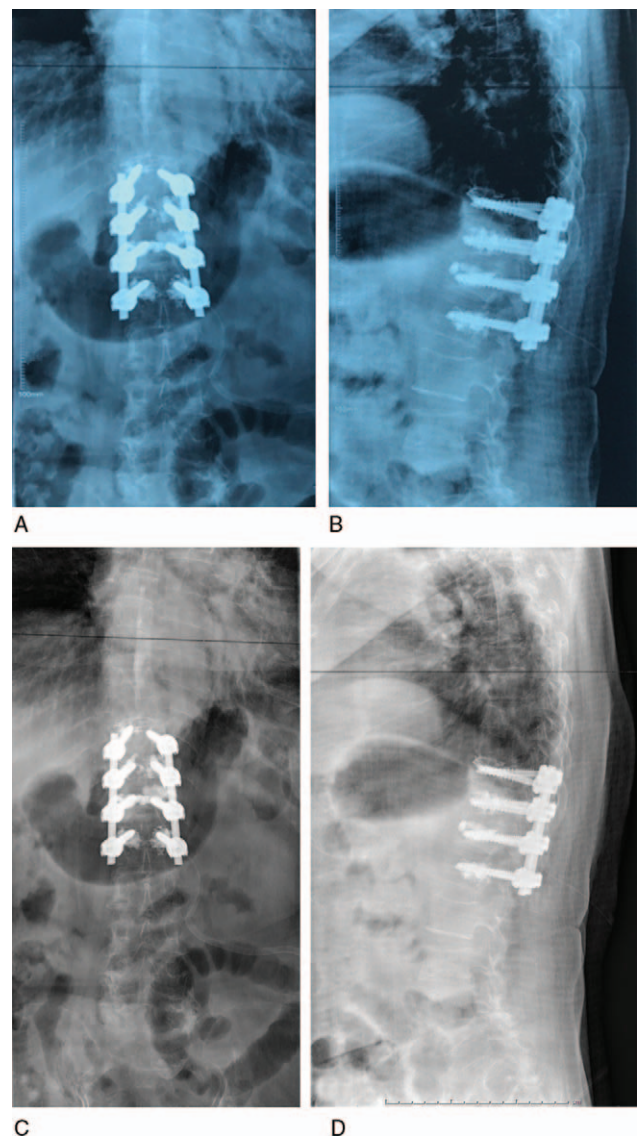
(A and B) Front and lateral x-rays in 1 week after operation. (C and D) Front and lateral of x-rays in 6 months after operation.
